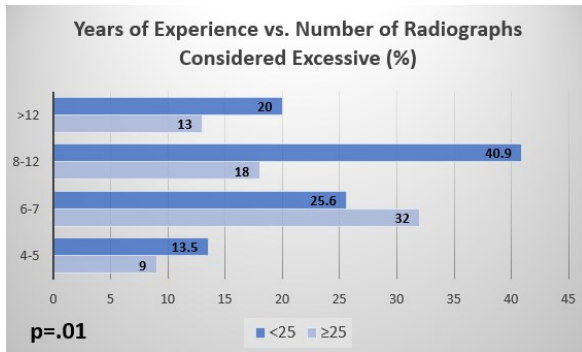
Comparison between years of experience and the number of radiographs considered excessive by respondents.
